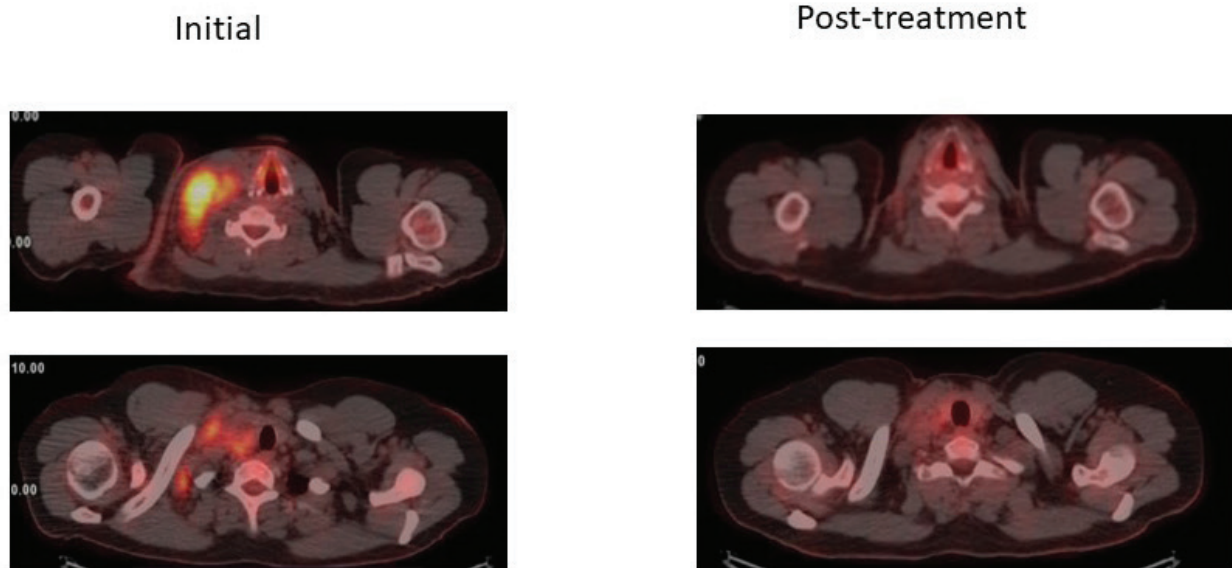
Initial evaluation-Right supraclavicular lymph node blocks (size 8X6cm) with high-grade uptake (SUVmax=12,8). Multiple enlarged lymph nodes (diam. >1cm) in right subclavicular, axillary area, and right upper paratracheal with high-grade uptake (SUVmax=8,1). End treatment evaluation- All lymph node blocks are decreased in size. Right supraclavicular lymph nodes with low-grade uptake (SUVmax=2,6). Enlarged lymph nodes (diameter 1,3cm) right subclavicular and axillary area, right upper paratracheal with no uptake (SUVmax=1,8).
